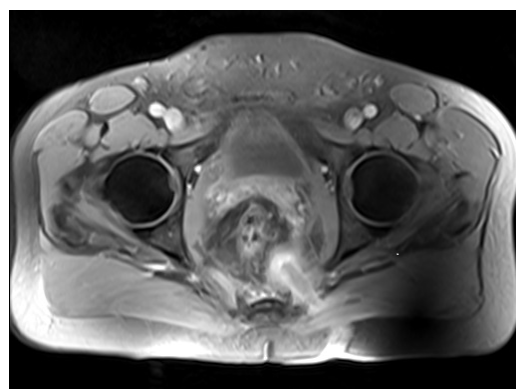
Axial contrast-enhanced T1-weighted image reveals fistula tract; external opening arising from the lateral gluteal region with supralelevator extension, and peripheral contrast enhancement.
